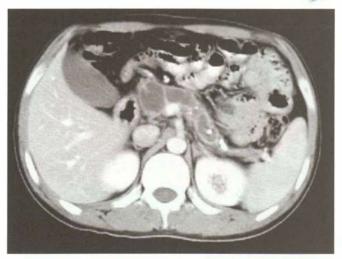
CT shows dilated pancreatic duct of 10 mm in size with stones. ERCP is not required in such patients. This patient underwent LPJ
